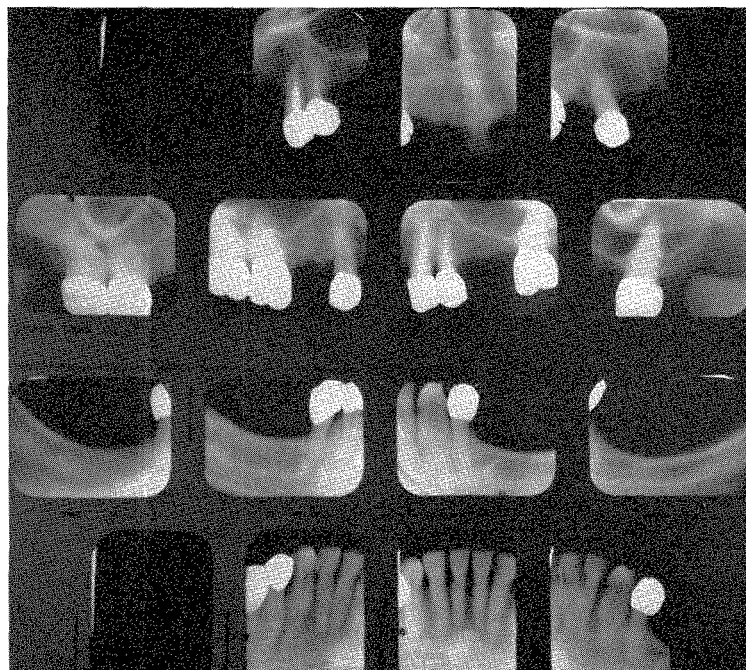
Roentgenograms which were taken at the completion of the work.
